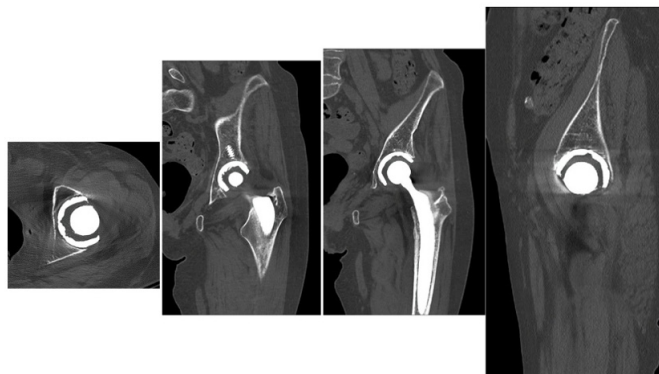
CT scan of the left hip. Images suggestive of fluid can be seen around the iliopsoas muscle tendon at its insertion into the lesser trochanter.
